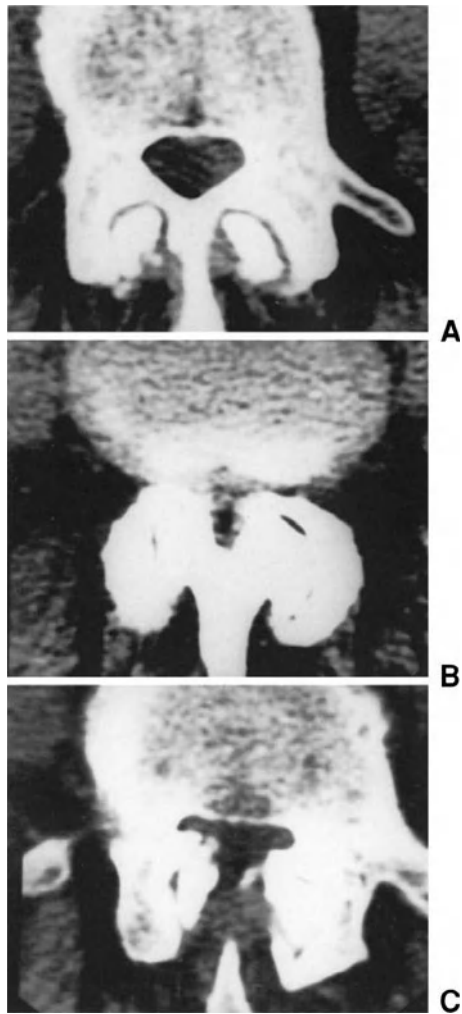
Stenosis of the spinal canal at L4-L5 level. The axial CT scan at the level of the pedicle of the L4 vertebra (A) shows that the spinal canal has a normal width, whilst the scan at L4-L5 level (B) reveals marked narrowing of the canal, which again shows normal dimensions at the level of the pedicle of the L5 vertebra (C).
